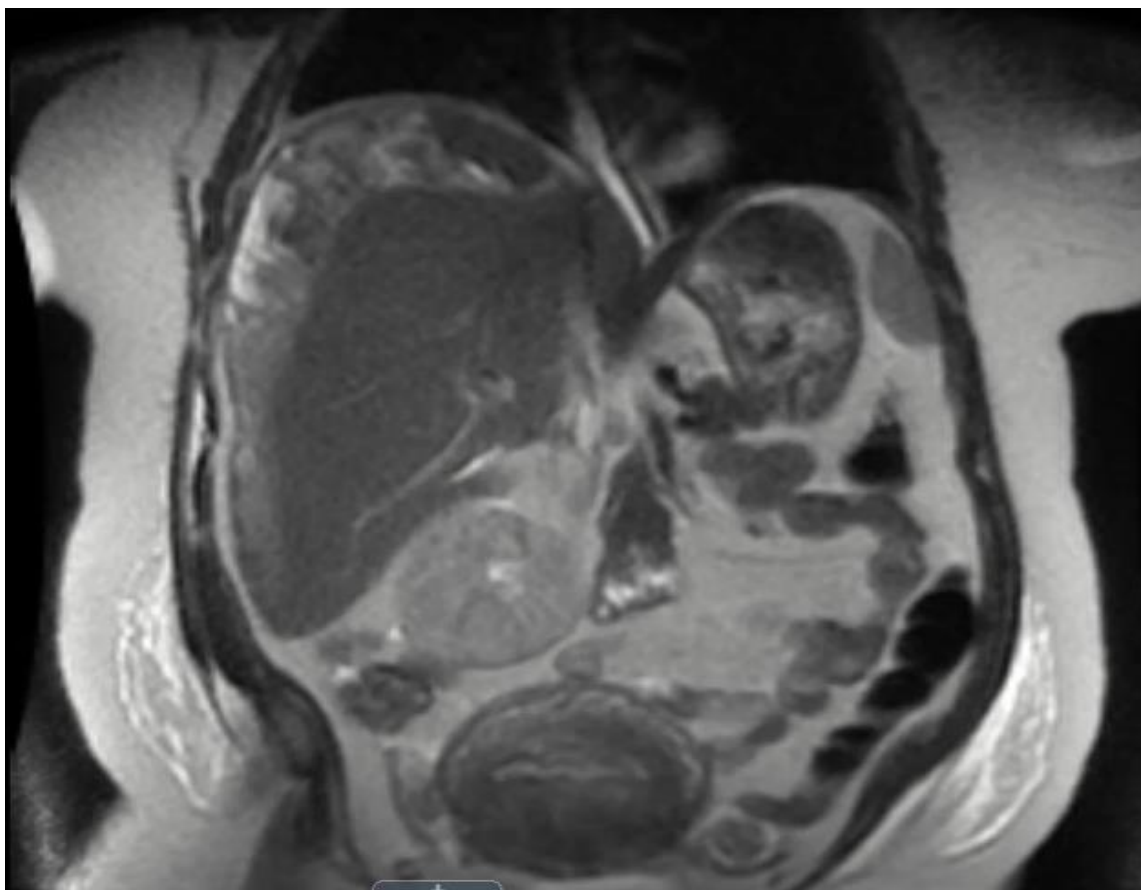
Coronal section of MRI with IV contrast (Liver mass protocol) of abdomen and pelvis demonstrates subcapsular hepatic hematoma involving the hepatic dome and right hepatic lobe, approximately measuring 24 cm in craniocaudal dimension.
